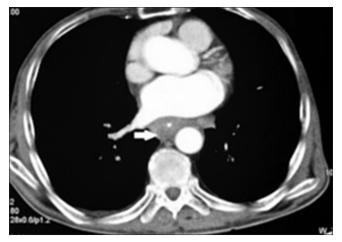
Contrast enhanced computed tomography: Marked wall thickening of the esophagus at the site of narrowing
